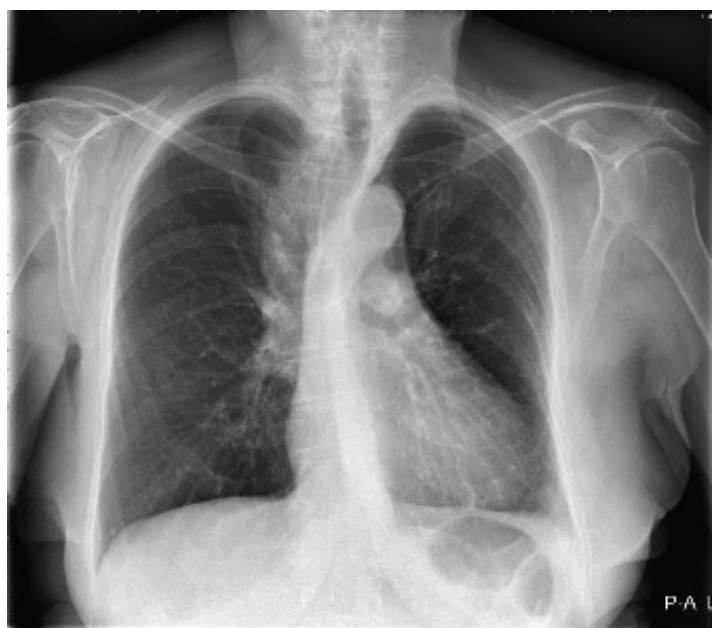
Patients' chest X-ray.
